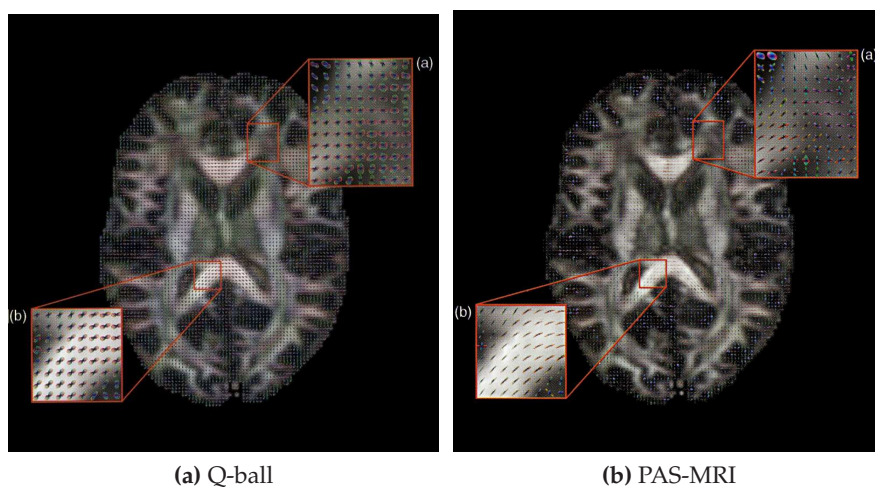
Image (a) shows the dODF resulting from Q-ball reconstruction. fODFs approximated from PAS-MRI reconstruction are shown in (b). Images adopted from [JBB09, pp. 63, 66].
